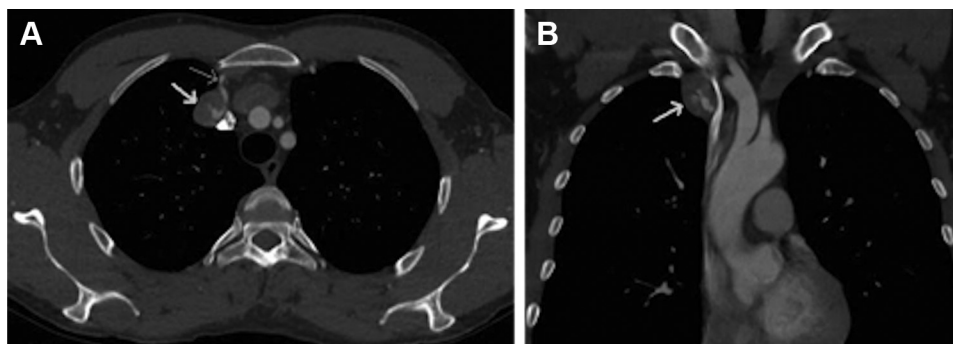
Computed tomography angiography (CTA) showing a 31- × 25- × 25-mm vascular lesion (*thick arrow*) arising from the right internal thoracic artery (ITA; *thin arrow*) on axial (A) and coronal (B) views.
